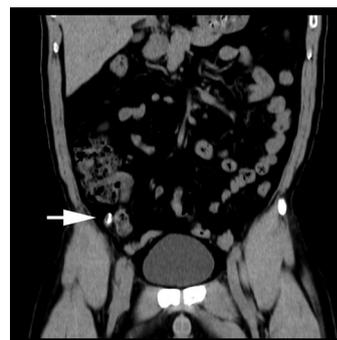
CT of the abdomen and pelvis, indicating a hyperdense structure located in the ileocecal region 5 days after the C+ file was swallowed (arrow).
